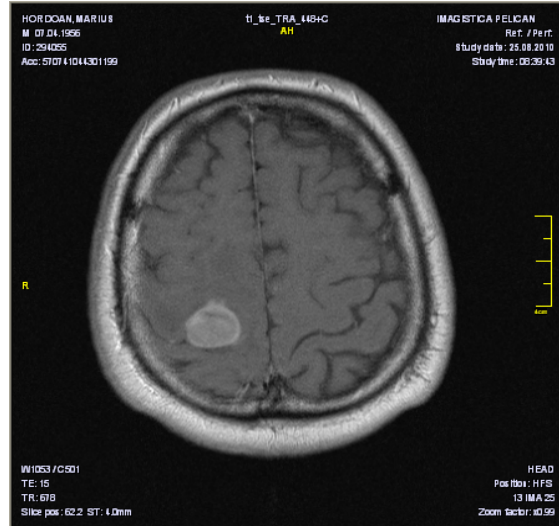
Preoperative enhanced MRI and postoperative contrasted CT scan of a lobar anaplastic astrocytoma
